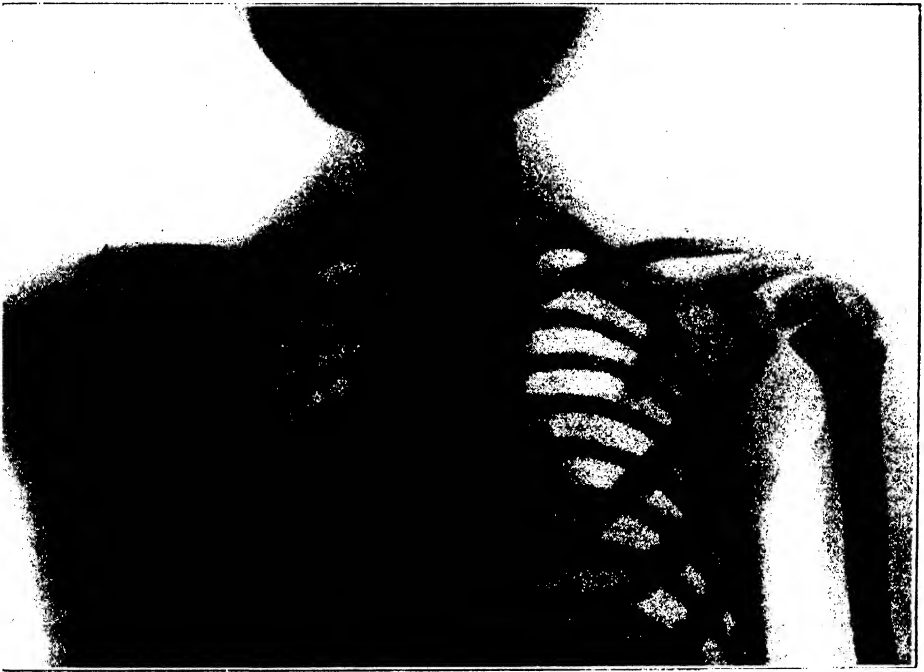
Radiograph of a coin impacted in the œsophagus. (JALAGUIER, *Soc. de chir.*, 1897).
